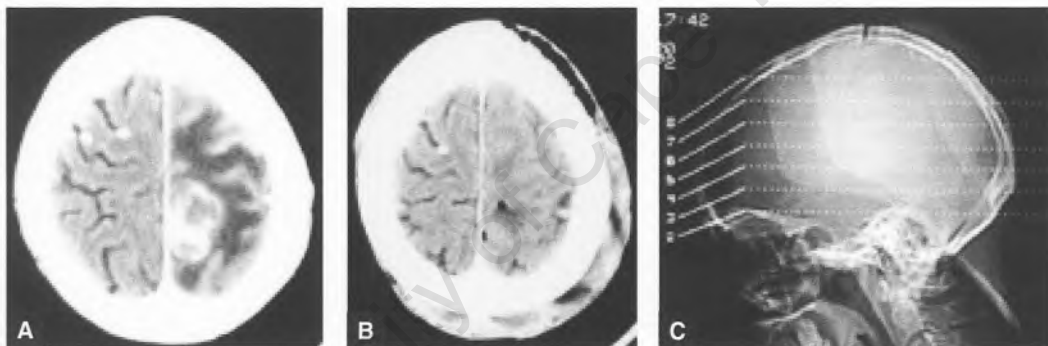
Axial CT scan showing the 20x 30 mm enhancing lesion (a) which was removed in its entirety (b) via a small craniotomy (c) which was placed with stereotactic guidance.
